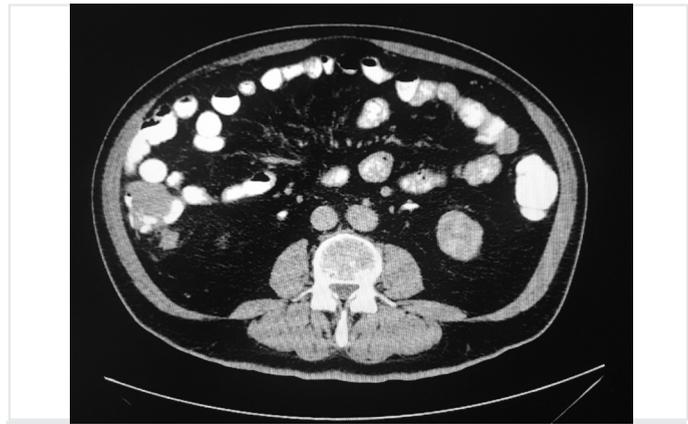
Computed tomography image
